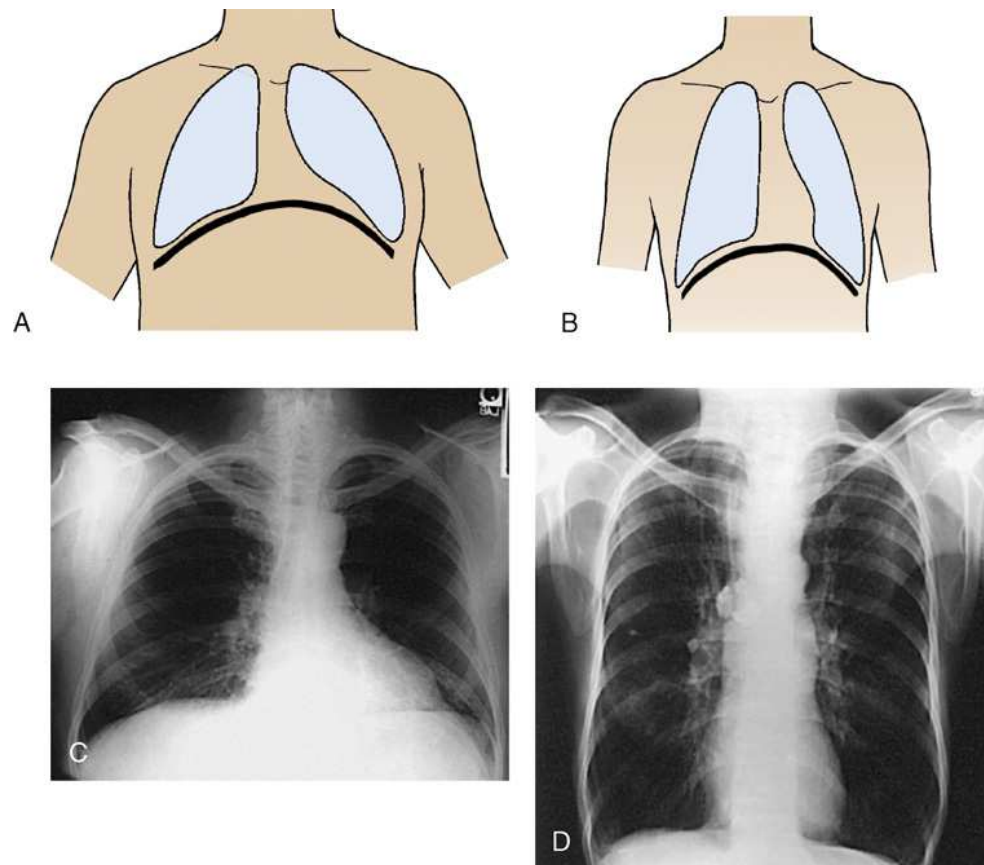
Diaphragm position and body habitus. (A) A hypersthenic patient has a diaphragm positioned higher. (B) An asthenic patient has a diaphragm positioned lower. (C) Chest radiograph of a hypersthenic patient. (D) Chest radiograph of an asthenic patient. Note position of diaphragm on these extremely different body types.
